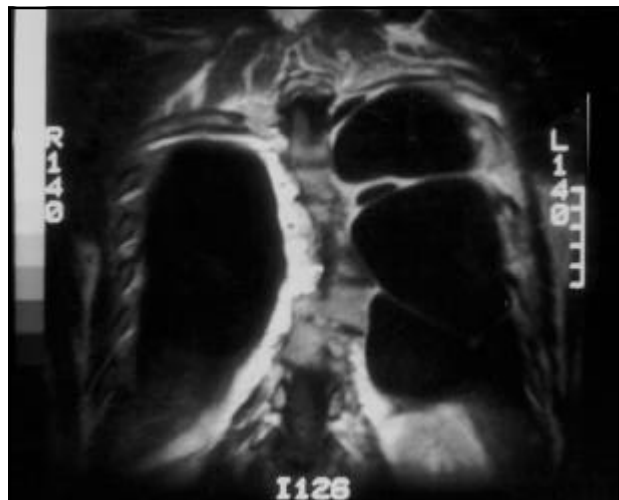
A coronal thorax MRI showed a three big cystic tumors on the left hemithorax.
